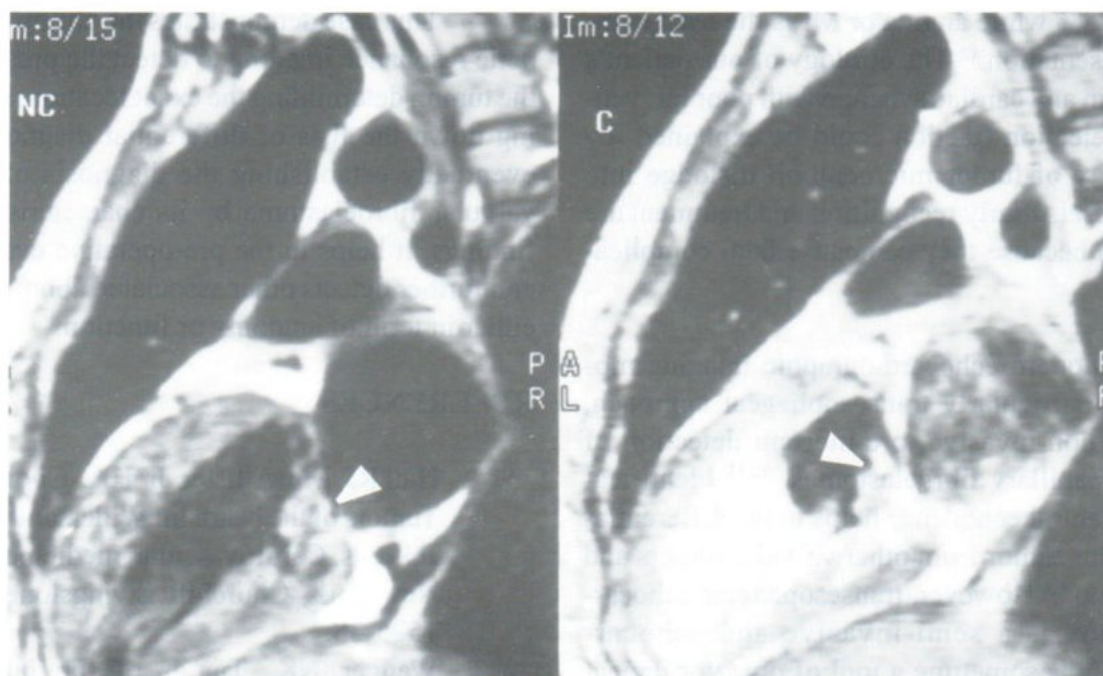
MRI SE T1W pre gadolinium (left) and post gadolinium (right) in sagittal oblique plane demonstrated further details of the mass which showed a central core of hyposignal and peripheral frond-like appearance of iso to slight hypersignal on T1W (left). Gadolinium SE T1W revealed a peripheral enhancing frond-like peripheral part (right).
